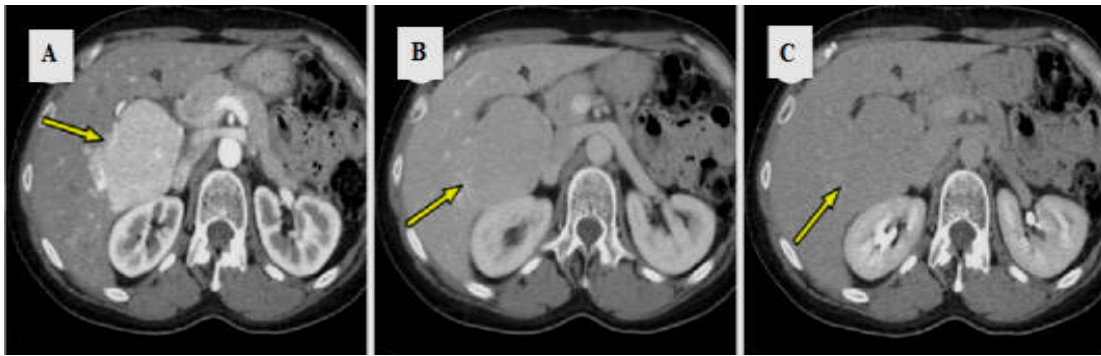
Focal nodular hyperplasi lesion (arrow) A) lesion on the arterial-phase CT image is hyperattenuated to the liver, B) lesion on venous-phase CT image is isodense to the remainder of the liver and C) lesion on the delayed-phase image is isodense to the liver (Kamaya et al., 2009)
